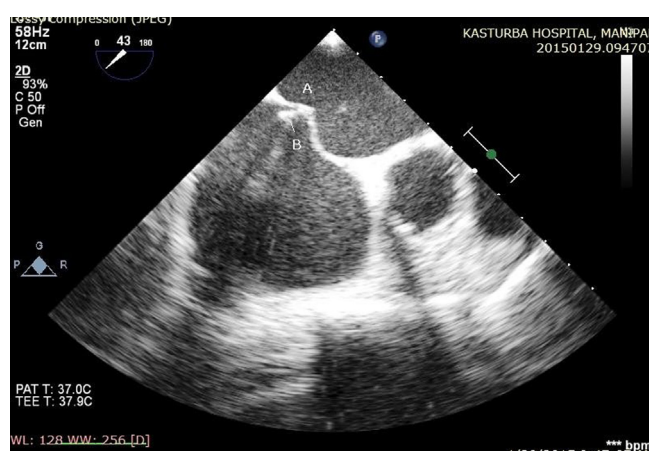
Transesophageal echocardiography-guided transseptal puncture which is posterior and inferior to the fossa ovalis (A – tenting of the atrial septum; B – brockenbrough needle).
